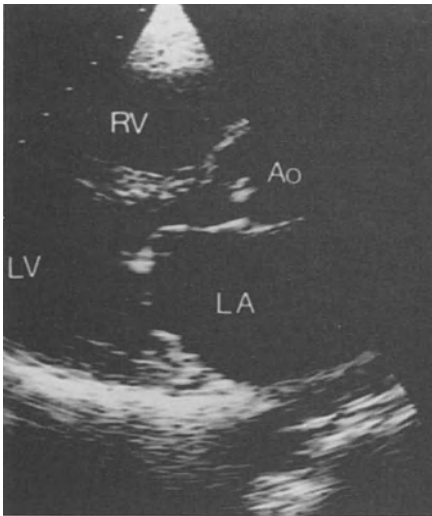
2D Echocardiogram: Long axis parasternal view; mitral stenosis, showing doming of thickened leaflets and enlarged left atrium.
